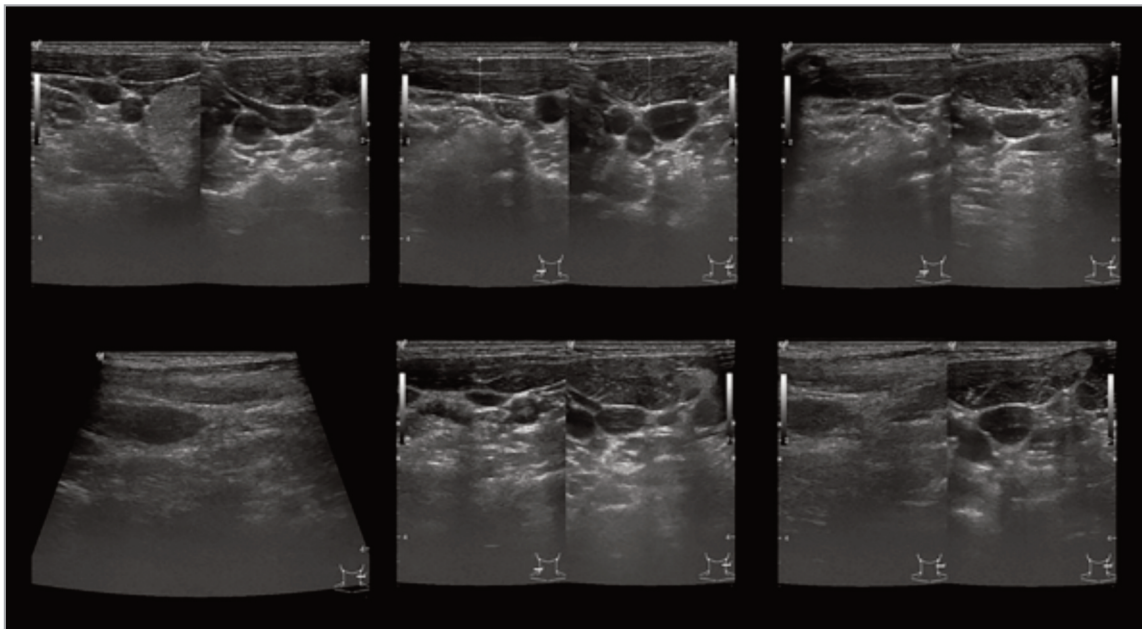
Neck's soft tissue ultrasound.
